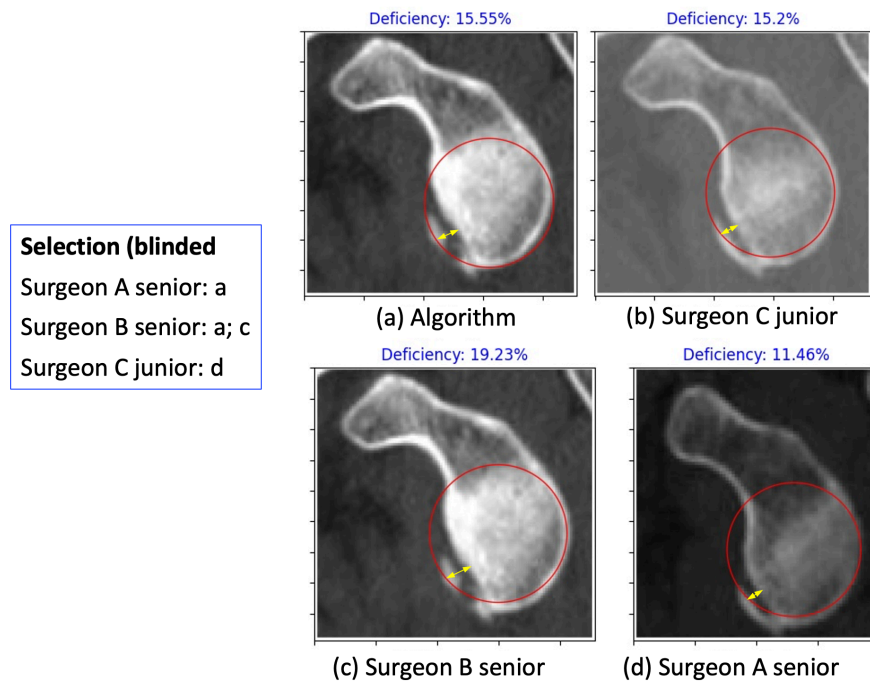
Selection of the best-fit circle (red) and the largest radial distance between the glenoid contour and the best-fit circle (yellow) on the oblique CT slice where the glenoid appears largest by three surgeons: Surgeon A senior, Surgeon B senior, Surgeon C junior): (a) computed annotation; (b)-(d) manual annotations of each one of the surgeons; The computed GBL % ratio (Deficiency) is shown above each. Each surgeon had to choose one of the annotations – two if he found that the annotations were indistinguishable (left box).
